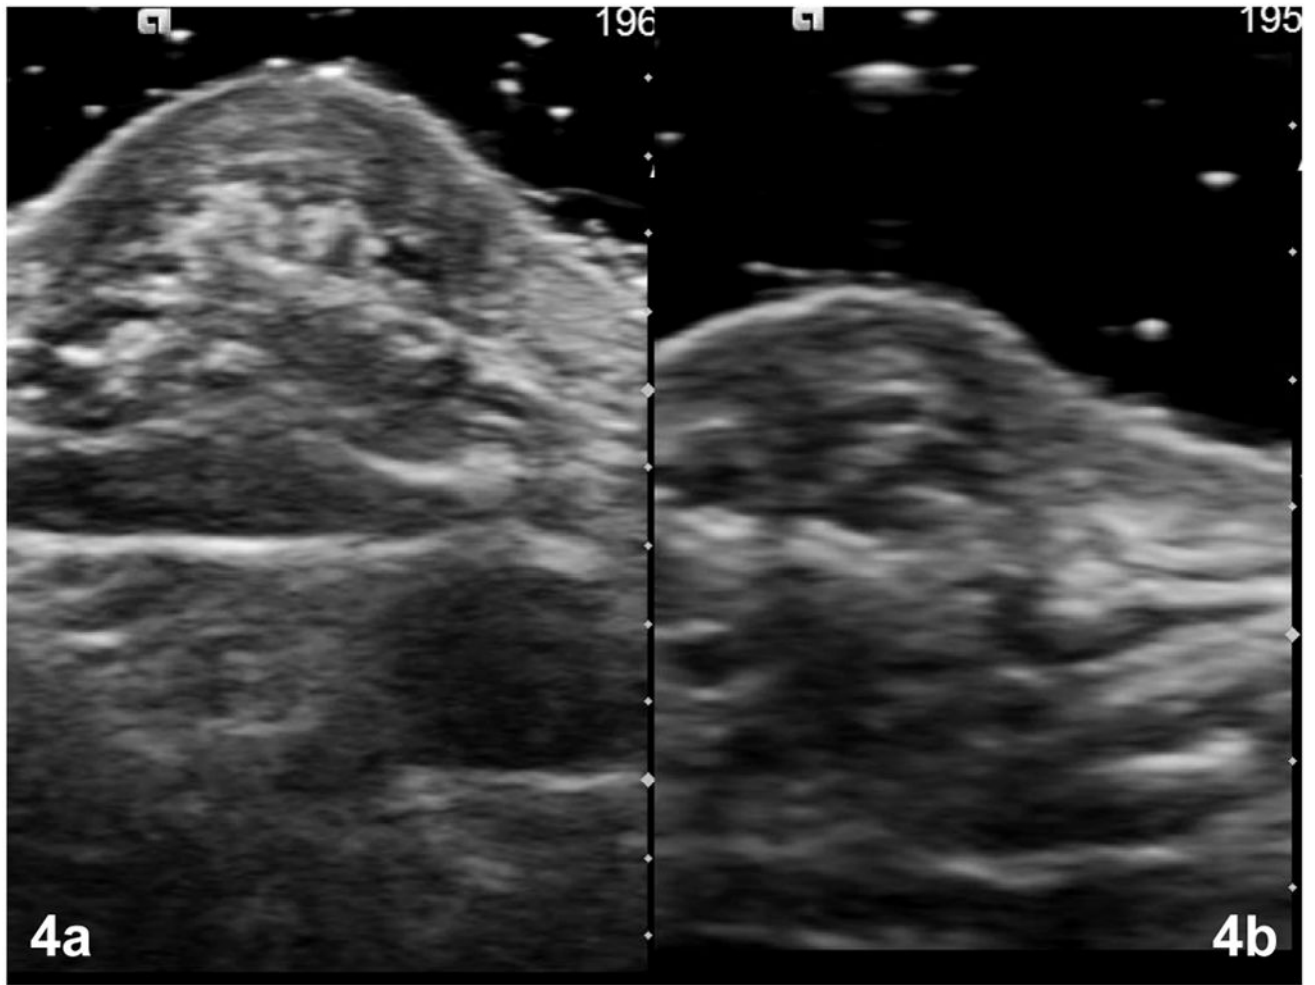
Ultrasound images of the axillae of the AWS affected extremity in a (a) 42 year-old woman and (b) 52 year- old woman, both of whom had a focal skin lump near the cord on exam.
